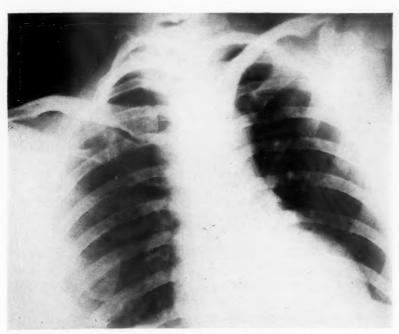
Case 2: Roentgenogram showing two well-developed cervical ribs. The left one is short and does not articulate with the first rib. The right one is very large, long, and articulates with the first rib.
